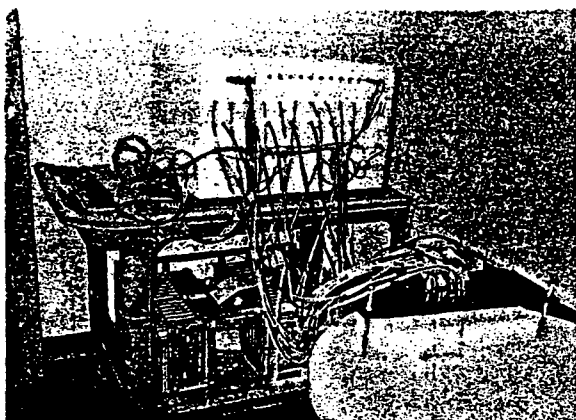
Picture of our combined system. NIR system (top) and ultrasound system (bottom) are mounted on a hospital cart.
